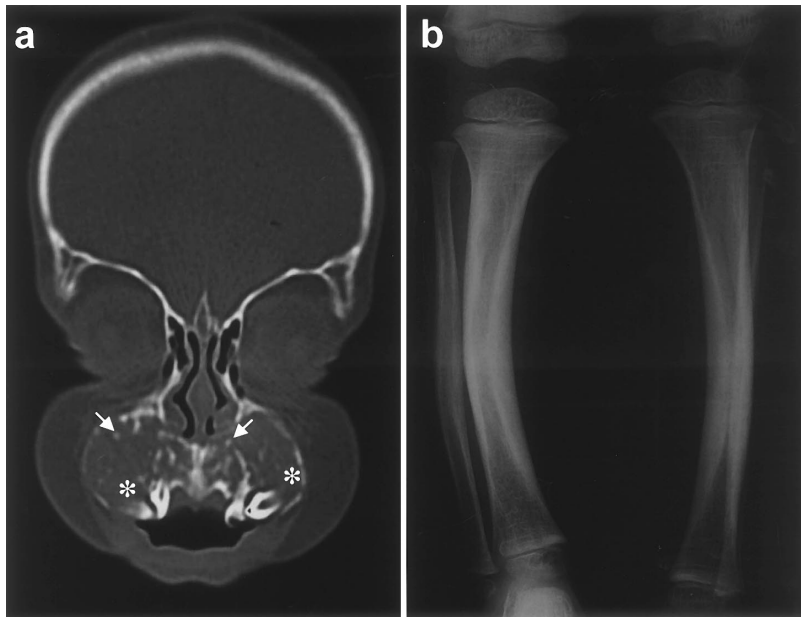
Radiological findings. A coronal computed tomography (CT) scan with bone windows through the midmaxilla (a) shows bilateral, relatively symmetrical expansile lesions of the maxilla. The lesions are composed predominantly of soft tissue (asterisks) with occasional punctate areas of calcification (arrows). An anteroposterior radiograph of the tibiae and fibulae (b) shows diaphyseal cortical thickening and lateral bowing.
